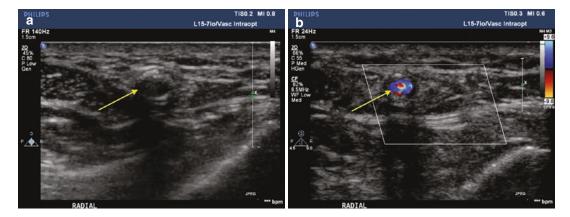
(a) Short-axis imaging the radial artery. (b) Short-axis imaging of the same patient with color flow Doppler imaging. The *yellow arrow* indicates the radial artery
